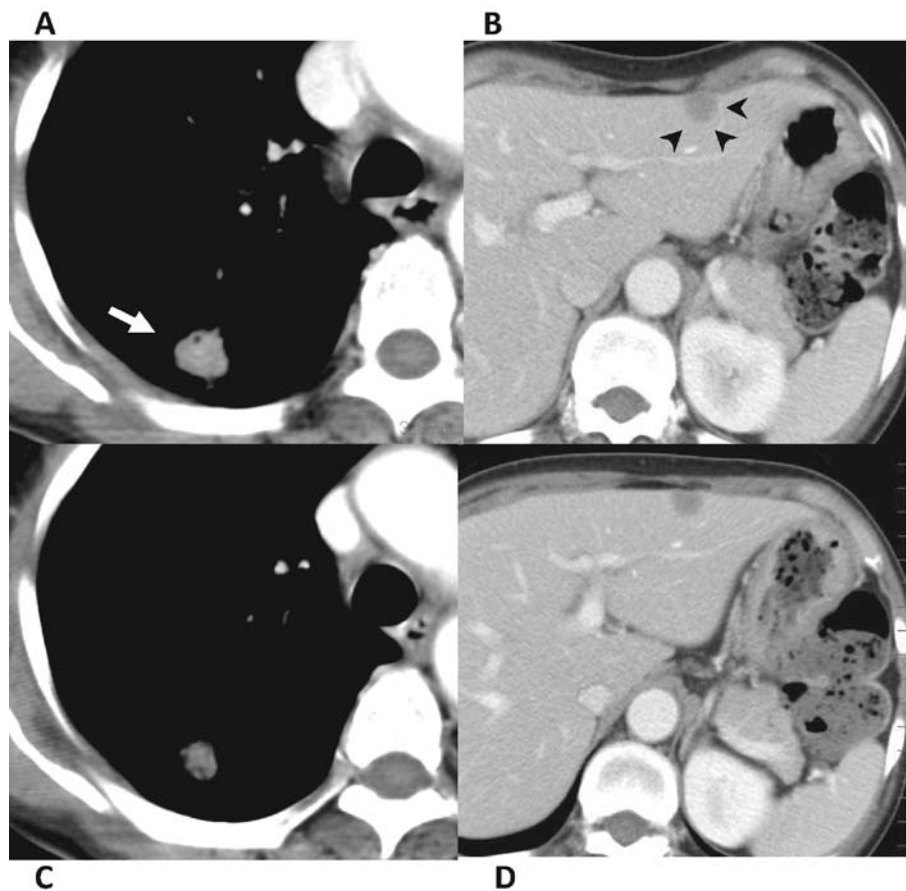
Lung/abdominal CT results obtained before (A and B) and after (C and D) ZOL therapy.
